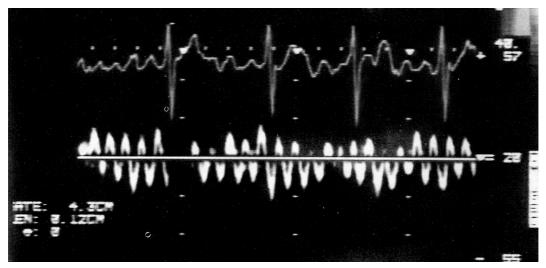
The pulsed wave doppler flow in the left atrial appendage before cardioversion showed a fibrillatory flow pattern.
